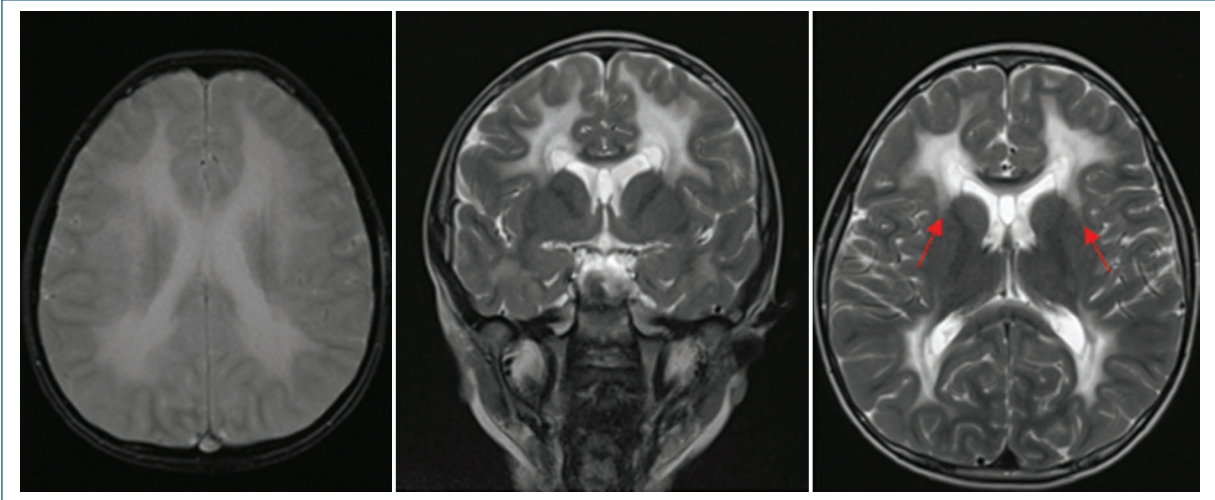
Brain magnetic resonance imaging in a patient with VWM leukoencephalopathy. Axial T2 sequence showing symmetric, confluent hyperintensities in the periventricular white matter (white arrows), with extension into subcortical fibers and temporal lobes. No contrast enhancement is observed. These findings are characteristic of vanishing white matter leukoencephalopathy.
